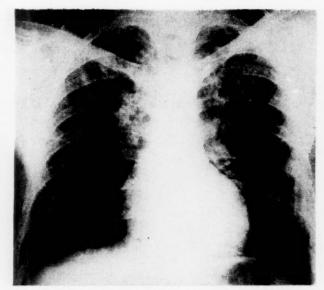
Case 1. Roentgenogram of the chest taken on October 13, 1953, showing some resolution of the process with right hilar prominence.
